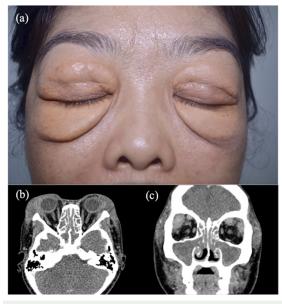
(a) Bilateral, symmetrical, ill-defined yellow, soft plaques without ulceration on upper and lower eyelids accompanied by swelling of periorbital areas of both eyes. (b, c) CT of the orbit showed enhancing soft tissue lesion of the bilateral extraconal compartment and both lacrimal glands, accompanied by pansinusitis.
